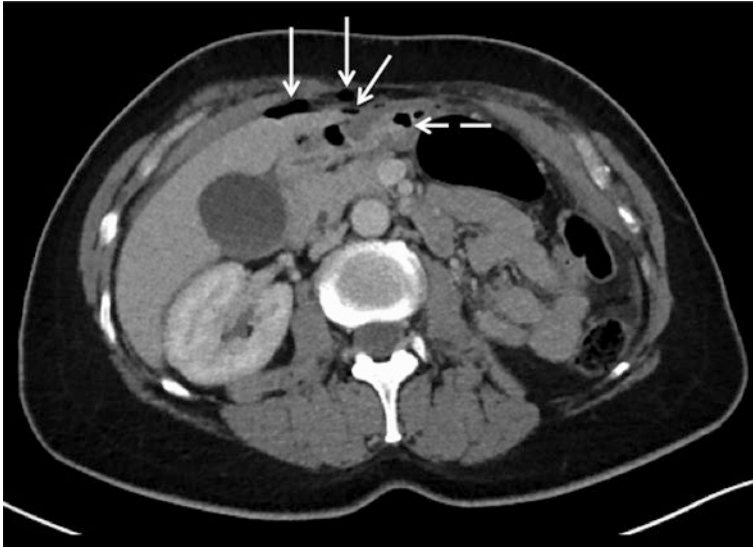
A 55-year-old woman presents with sudden-onset upper abdominal pain, peritonism and subdiaphragmatic free air on chest radiograph. Axial contrast-enhanced CT abdomen/pelvis demonstrates locules of free air (solid arrows) in the upper abdomen, adjacent to the liver and the distal stomach (dashed arrow), suggestive of gastroduodenal perforation
